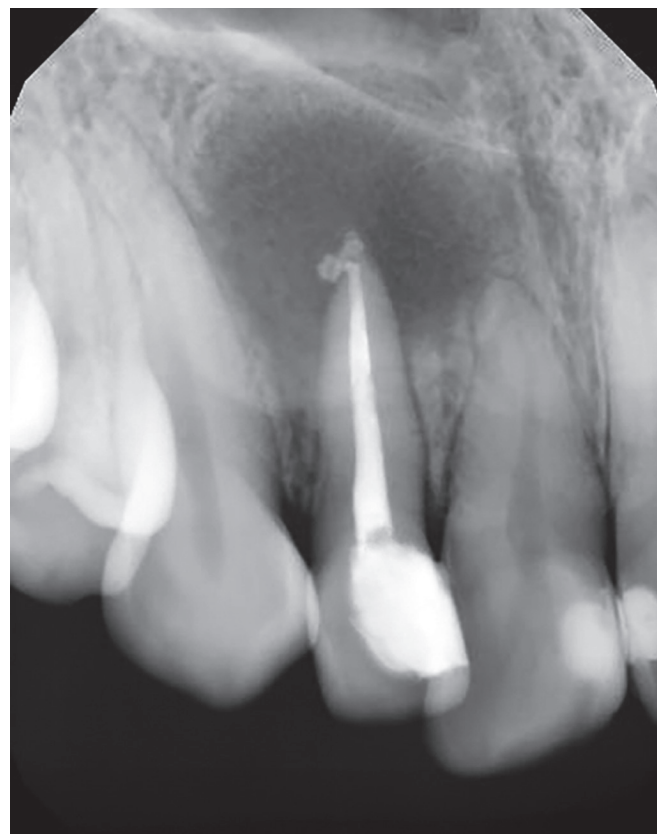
Root canal obturation control radiograph.
